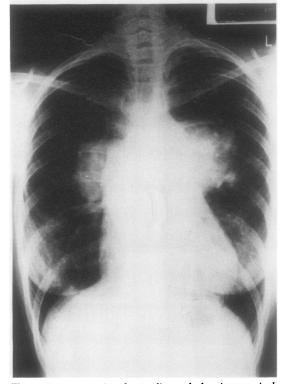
Anteroposterior chest radiograph showing massively dilated main pulmonary arteries.
